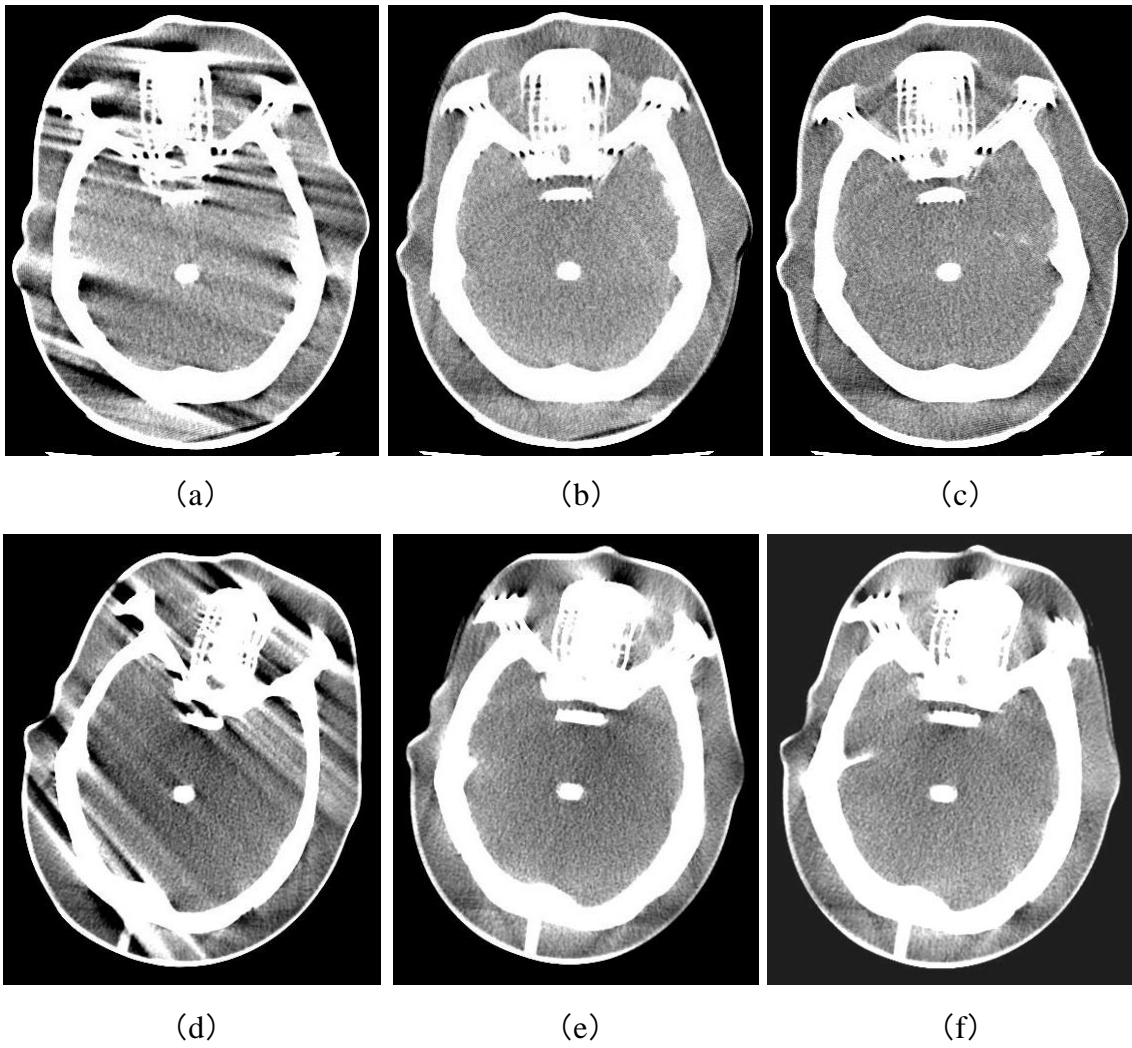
Representative images of motion artifacts generated using the (a) AS, (b) HS-64, and (c) HS-32 for the CT-A and (d) AS, (e) HS-64, and (f) HS-32 for the CT-B
